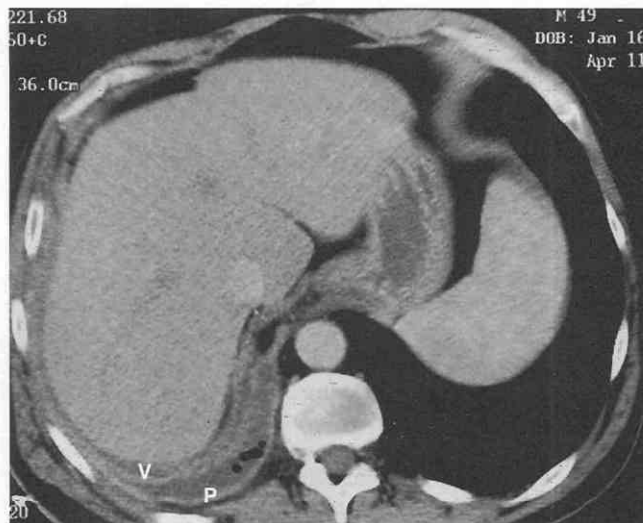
Empyema in a 49-year-old man. Contrast-enhanced CT scan shows the split-pleura sign with enhancement of the visceral (V) and parietal (P) pleura. Air bubbles are present in the empyema.
